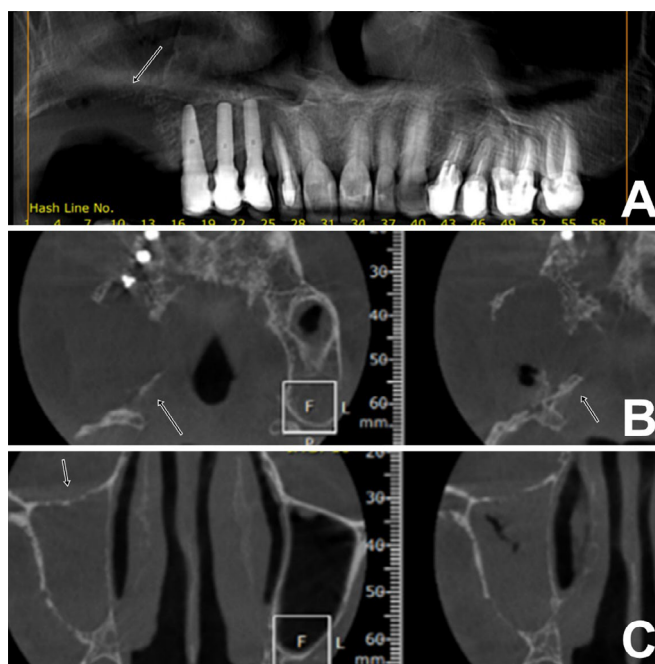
Cone-beam computed tomography displaying an osteolytic lesion (arrows) in the posterior maxillary region extending to the right maxillary sinus.
